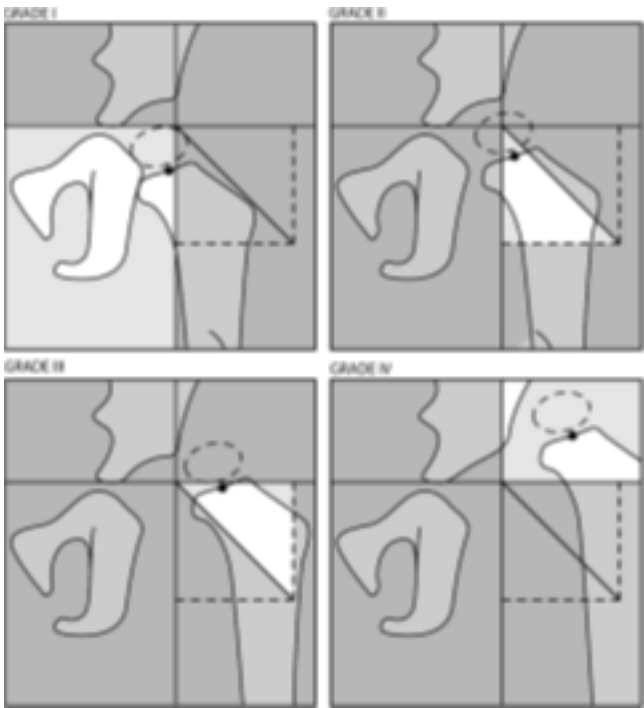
IHDI Classification (Narayanan, U., et al., Reliability of a New Radiographic Classification for Developmental Dysplasia of the Hip. *J Pediatr Orthop*, 2015. 35(5): p. 478-84).
